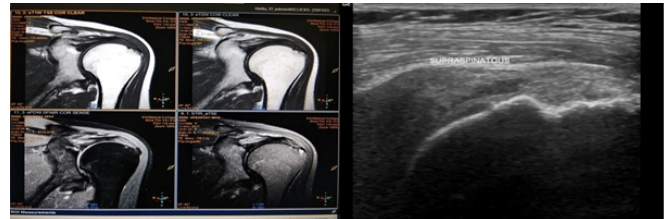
MRI Coronal (A) T1 W (B) T2 W (C) PDW and (D) STIR images showing Supraspinatus tendinosis evidenced by tendon thickening and intrasubstance altered signal intensity. Associated subarticular partial tear is noted as focal region of fluid collection (E) On USG, intrasubstance hypodensity noted consistent with partial tear.
